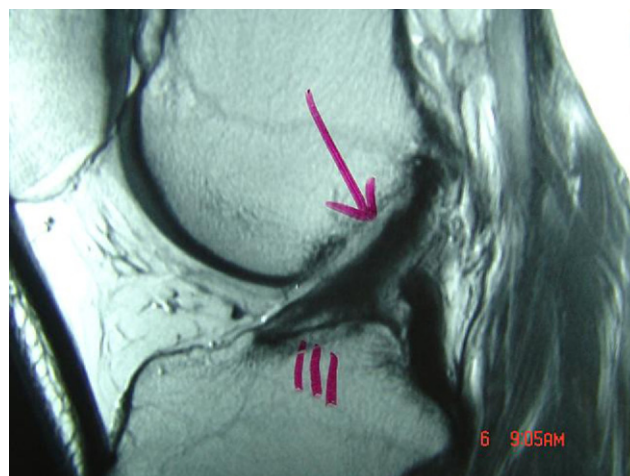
Sagittal MRI of patient in Fig. 1, 1 year later, demonstrating healing of the fragment and ligament. (Color version of figure is available online.)
